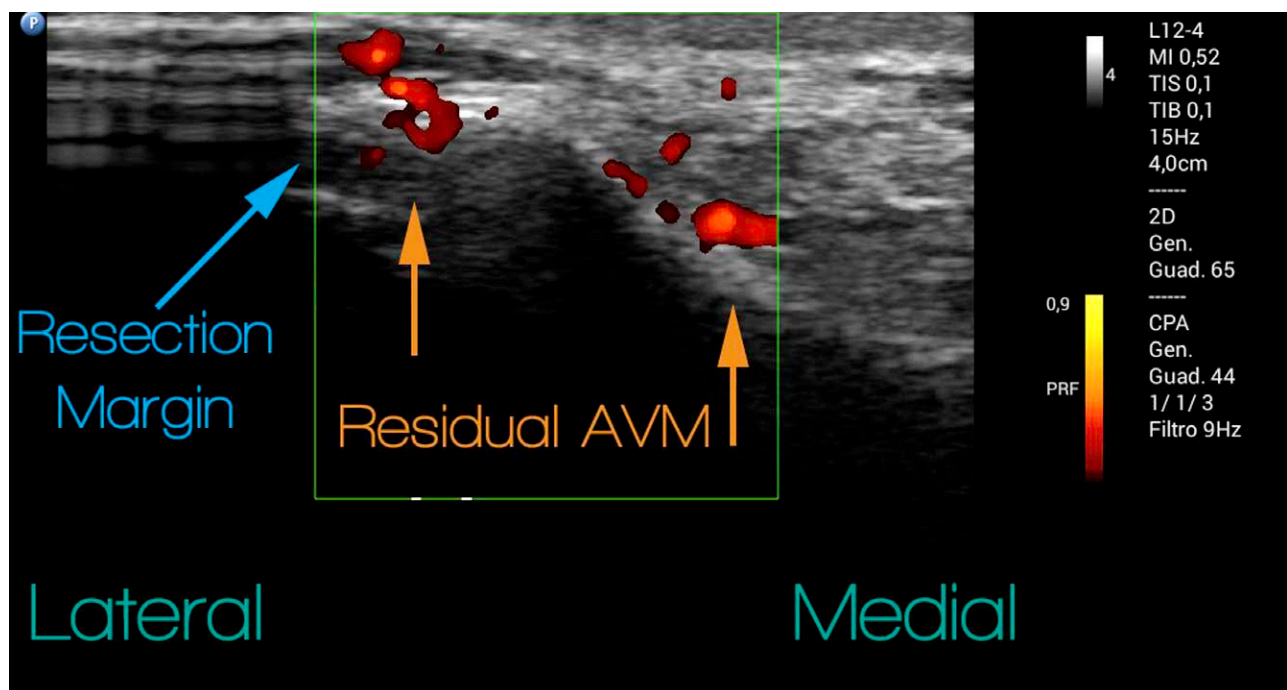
CDUS of the soft tissues medial to the resection. Residual disease is detected and the excision extended accordingly. CDUS indicates Color Doppler Ultrasound.
